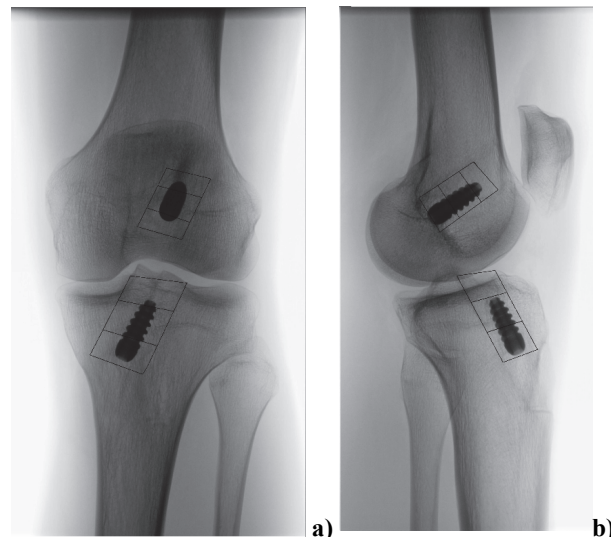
Radiographs of the knee.
